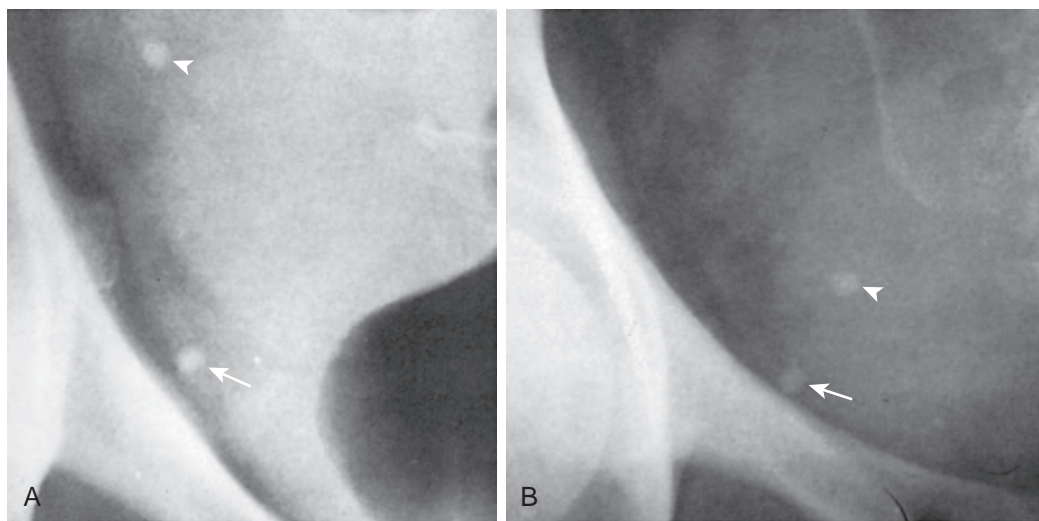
Mobility of ureteral calculus. A. A phlebolith (arrow) and ureteral calculus (arrowhead) are morphologically identical on the initial abdominal radiograph. B. However, the venous stone (arrow) maintains a fixed position, whereas the ureteral stone (arrowhead) has migrated distally on a subsequent radiograph.
